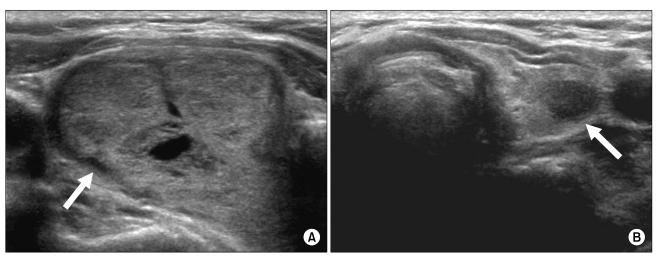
Ultrasonographic features of the bilateral thyroid nodules, axial view. (A) A 4.4 cm heterogeneous iso-echoic nodule on the right lobe and (B) a 1.2 cm low-echoic nodule on the left lobe (arrows) were noted.
